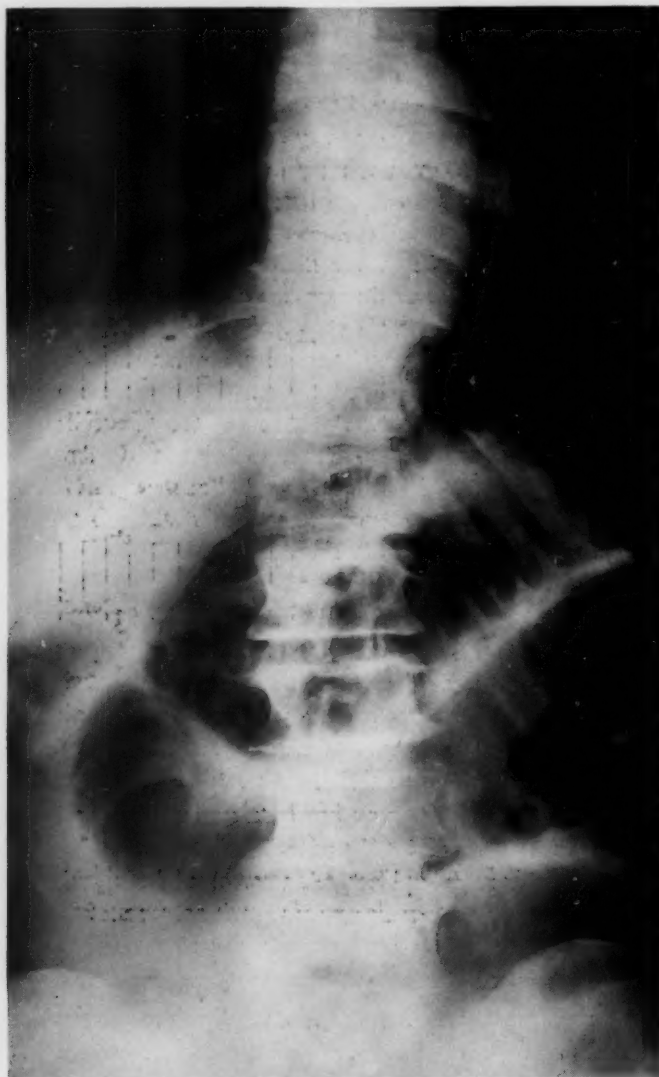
Case J. R.: Roentgenographic evidence of small intestinal obstruction.
